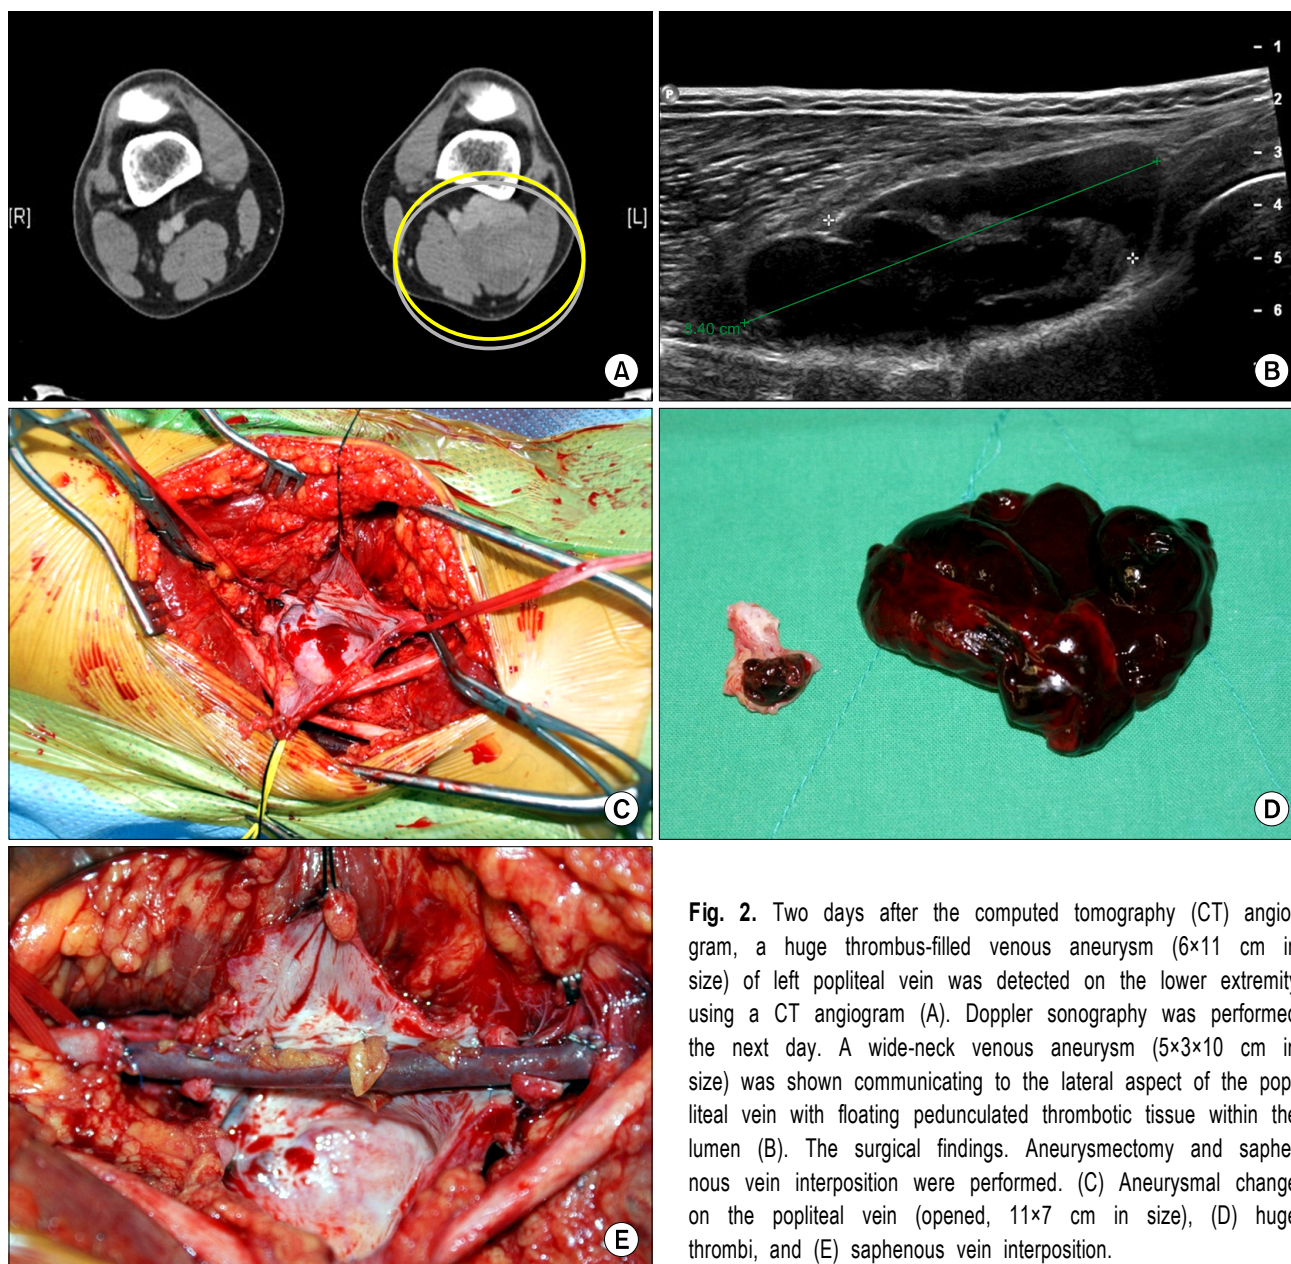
Two days after the computed tomography (CT) angiogram, a huge thrombus-filled venous aneurysm (6×11 cm in size) of left popliteal vein was detected on the lower extremity using a CT angiogram (A). Doppler sonography was performed the next day. A wide-neck venous aneurysm (5×3×10 cm in size) was shown communicating to the lateral aspect of the popliteal vein with floating pedunculated thrombotic tissue within the lumen (B). The surgical findings. Aneurysmectomy and saphenous vein interposition were performed. (C) Aneurysmal change on the popliteal vein (opened, 11×7 cm in size), (D) huge thrombi, and (E) saphenous vein interposition.
